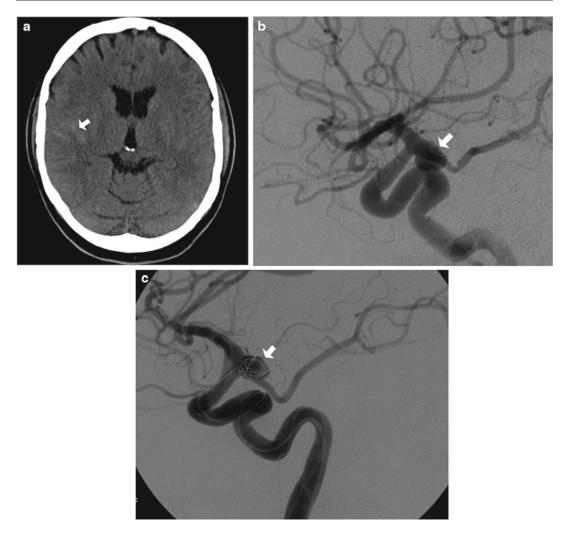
(a) Head CT scan reveals focal subarachnoid hemorrhage in the right sylvian fissure (*white arrow*). Conventional cerebral angiogram demonstrates a $6.5 \times 6 \times 5.4$ -mm aneurysm at the junction of the right
